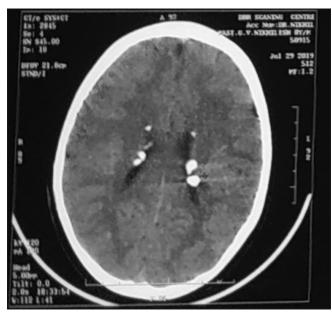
CT brain scan showing multiple subependymal nodules
